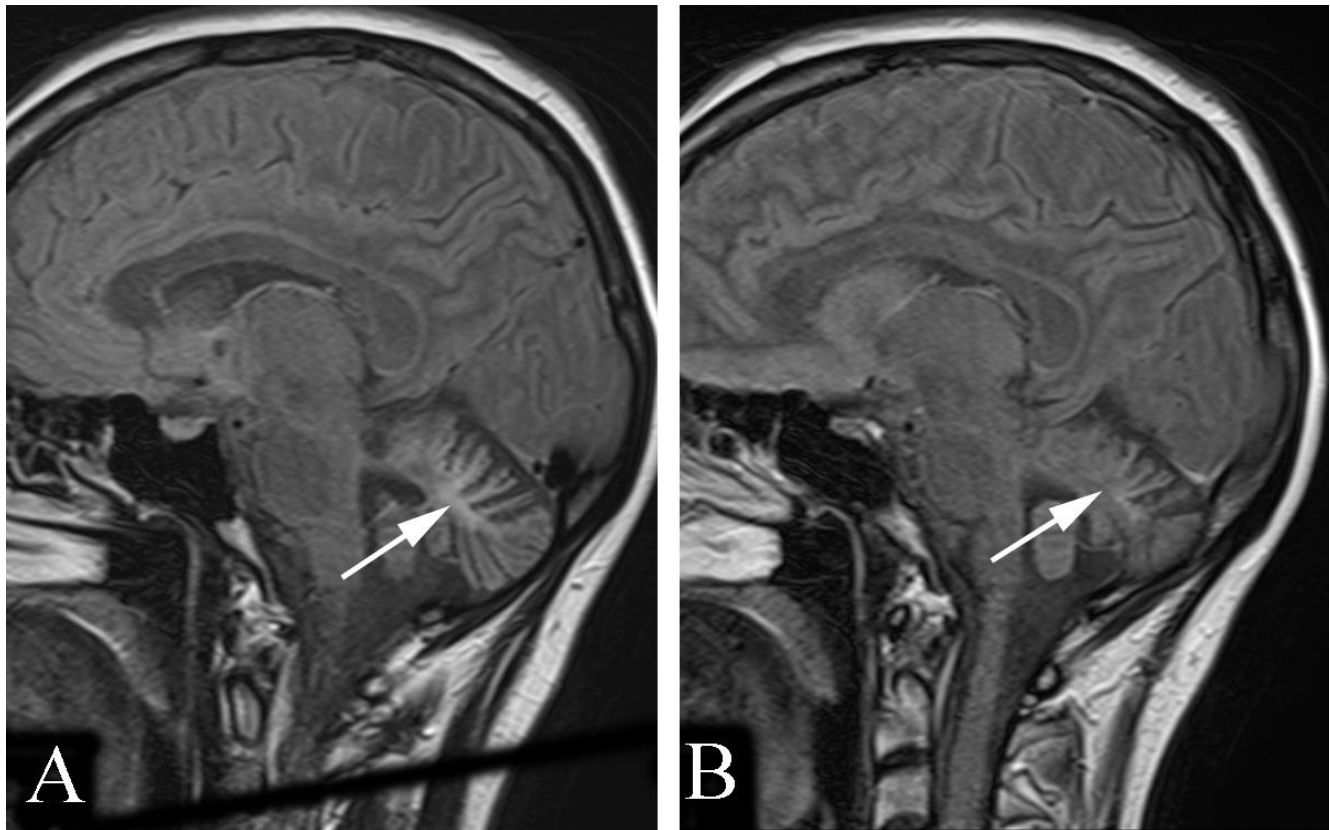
Viral cerebellitis in a 48 year old woman with unsteady gait, dizziness, and blurred vision. A Sagittal magnetic resonance FLAIR image through the right cerebellar hemisphere shows abnormal signal (arrow). B. Sagittal magnetic resonance FLAIR image through the contralateral cerebellar hemisphere shows much less abnormal signal (arrow). The patient had viral meningitis six years before the onset of symptoms.
